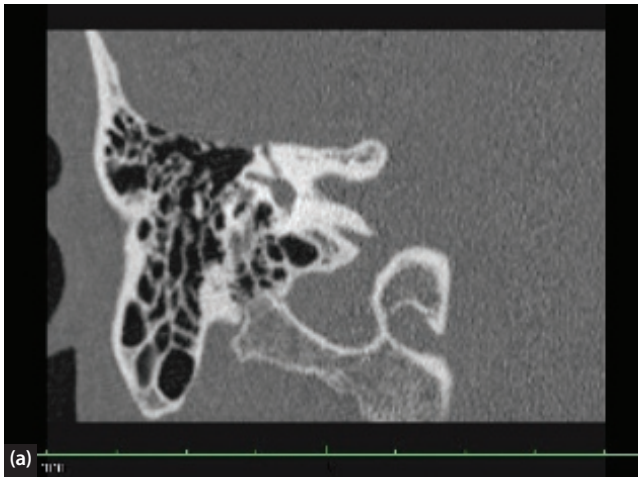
CT images of dehiscent right superior semicircular canal. (a) Coronal, (b) oblique coronal reformat in plane of SSC ('Pöschl view').
